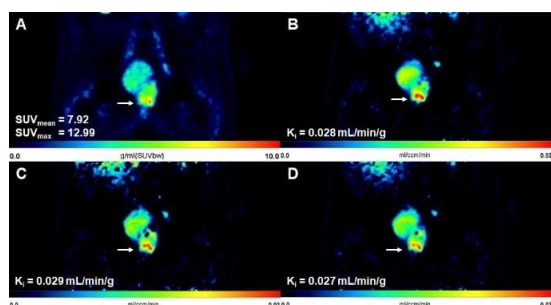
Coronal images of a prostate cancer patient. The SUV image (A), 60-min parametric K_i image (B), 5-min DTP parametric K_i image (C), and 10-min DTP parametric K_i images (D).
